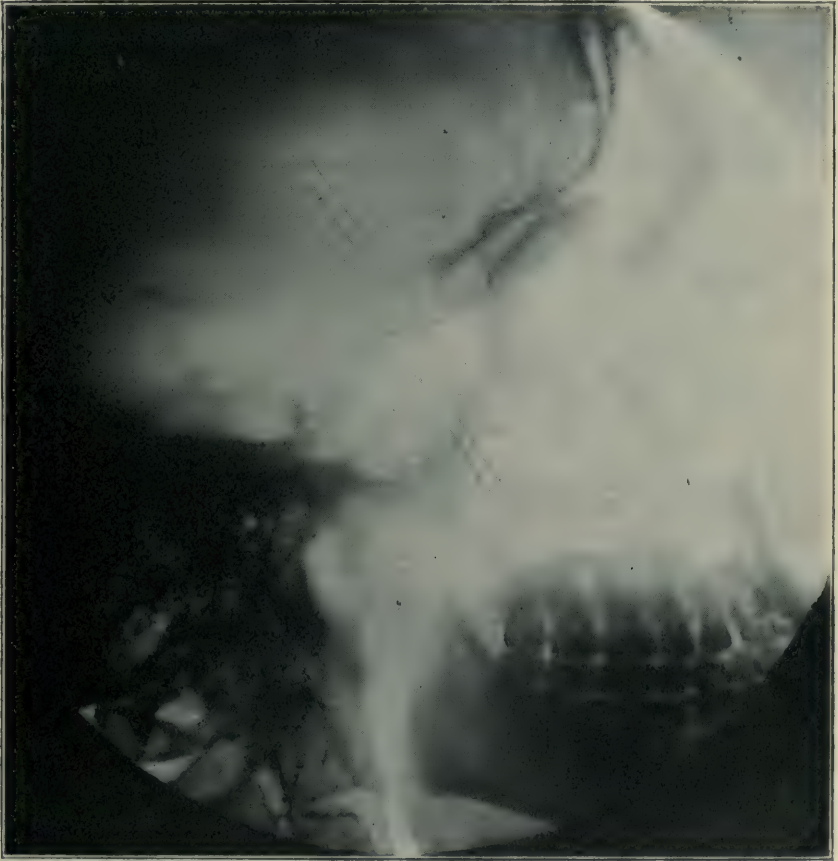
Roentgenogram of skull of patient shown in Figures from 1 to 5, inclusive. The shadows in the pineal region are marked (Patient 24, Fig. 11).
